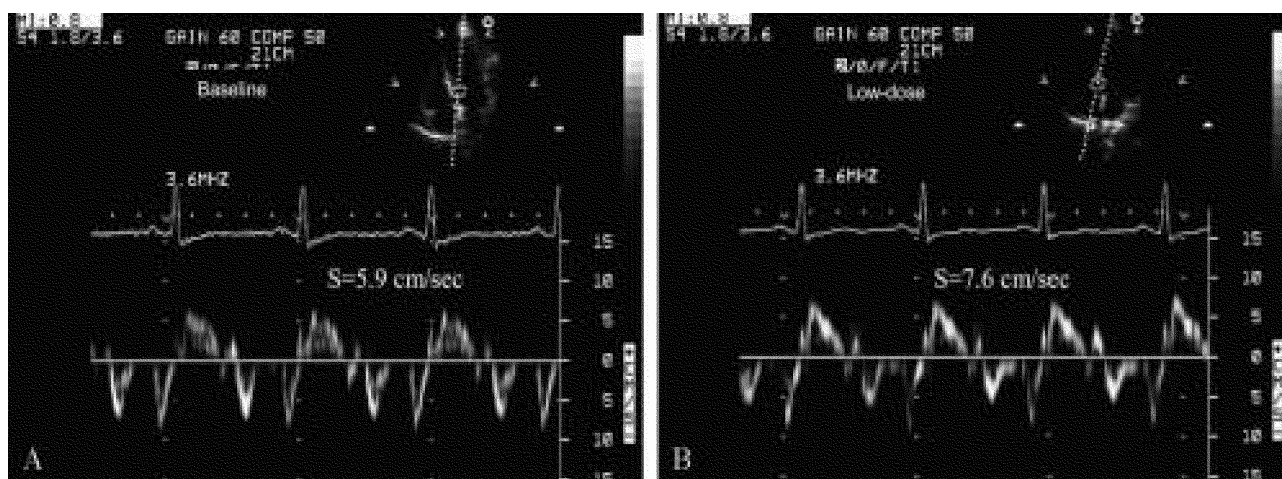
Assessment of myocardial velocities using tissue Doppler imaging. An increase in the systolic velocity (S, from 5.9 cm/s to 7.6 cm/s) during dobutamine infusion indicates the presence of myocardial viability.
